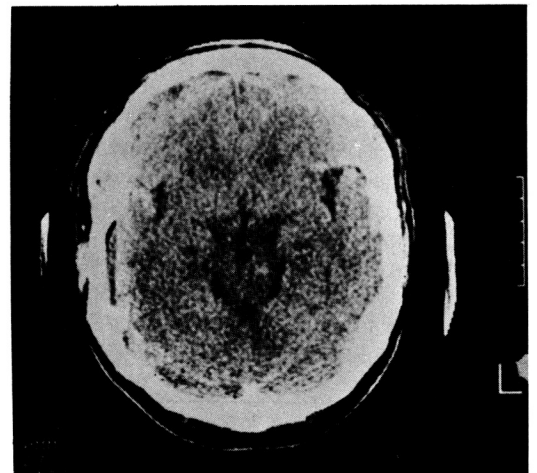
CT defines a pinpoint left lower tegmental midbrain hemorrhage.
